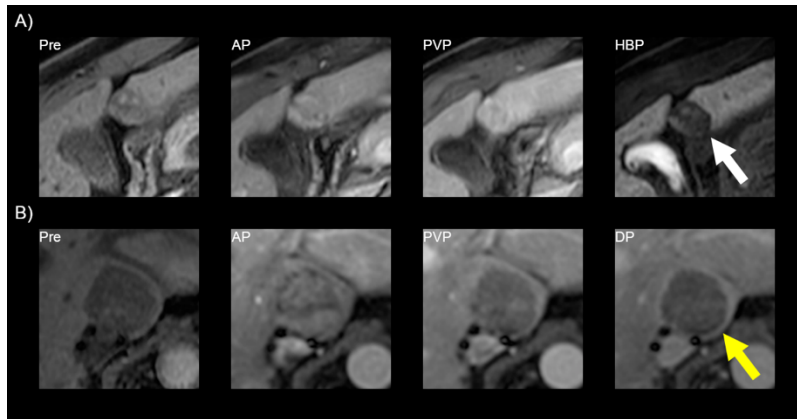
MR images showing examples where readers disagreed (A) and where readers agreed (B). The top row (A) shows images from an MR examination performed with gadoteric acid from a 56-year-old male with cirrhosis secondary to hepatitis C. From left to right: pre-contrast (Pre), arterial phase (AP), portal venous phase (PVP), hepatobiliary phase (HBP). This 21 mm hepatobiliary phase hypointense observation (white arrow) was characterized on the clinical read as having non-rim arterial phase hyperenhancement and washout appearance and was categorized as LI-RADS category LR-5 (definitely hepatocellular carcinoma [HCC]). The first research reader characterized it as having a targetoid appearance and categorized it as LR-M (probably or definitely malignant, not specific for HCC). The second research reader characterized it as having no major features and paralleling the blood pool and categorized it as LR-2 (probably benign). It was subsequently resected and found to be a well-differentiated HCC. The bottom row (B) shows images from an MR examination performed with an extracellular contrast agent from a 61-year-old female with cirrhosis secondary to hepatitis C. From left to right: pre-contrast (Pre), arterial phase (AP), portal venous phase (PVP), delayed phase (DP). This 31 mm observation (yellow arrow) in the caudate lobe was characterized on the clinical read as having arterial phase hyperenhancement, washout appearance, and capsule appearance was categorized as LI-RADS category LR-5 (definitely hepatocellular carcinoma). Both research readers also categorized this observation as LR-5. The patient passed away from intracranial hemorrhage a few months later.
